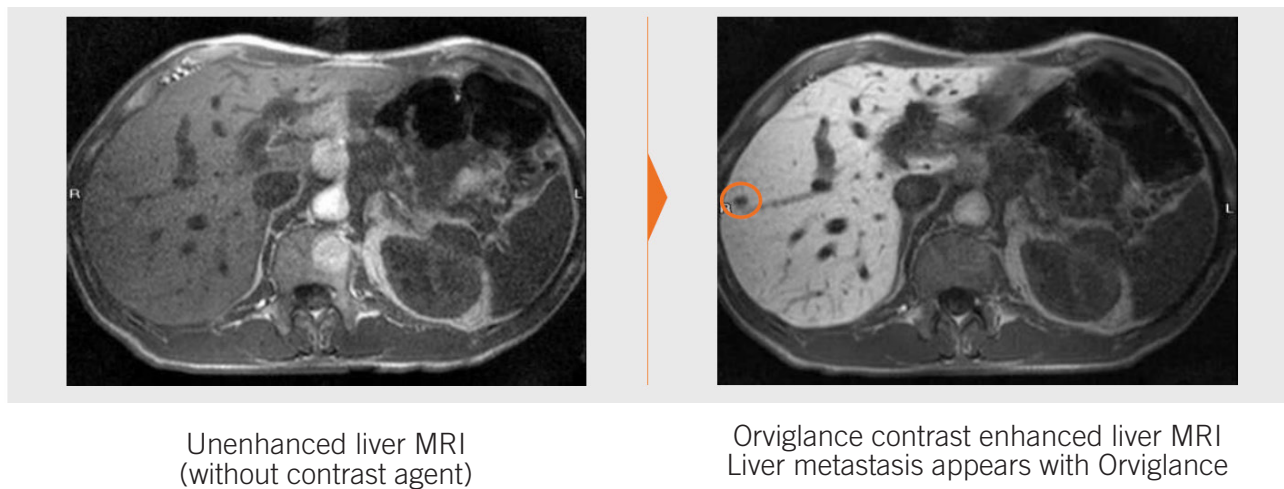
MRI images showing ability of Orviglance to aid detection of liver metastasis compared with unenhanced MRI
